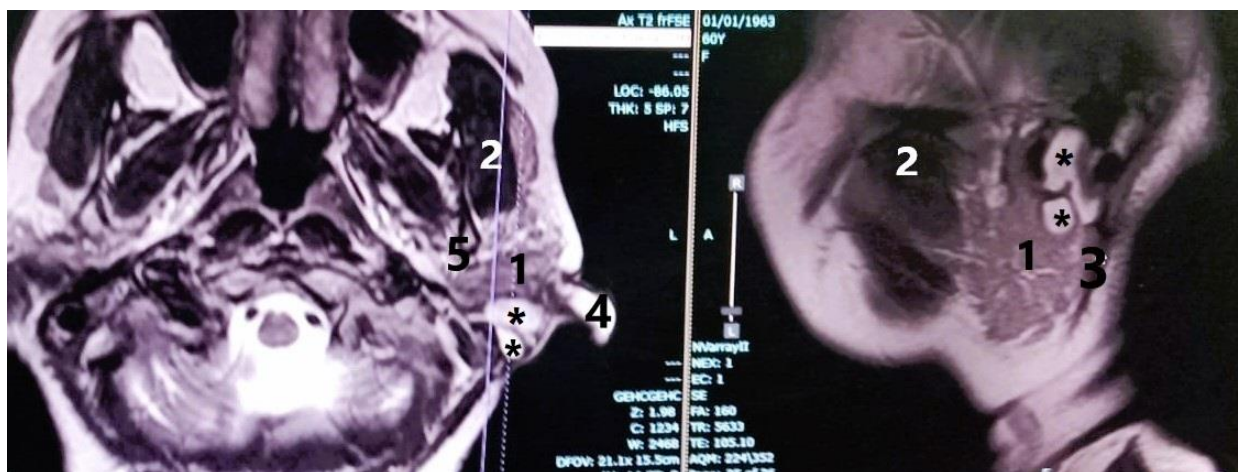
MRI scan Neck showing cyst and surrounding structures on T2 images in Axial and Sagittal sections (*- cyst, 1- Parotid gland, 2- Masseter muscle, 3- Sternocleidomastoid muscle, 4- Pinna, 5- Mandible) (Cystic lesion possibility of arising from Parotid gland lateral and superficial to Sternocleidomastoid muscle, part of it going deep below External Auditory Canal)
